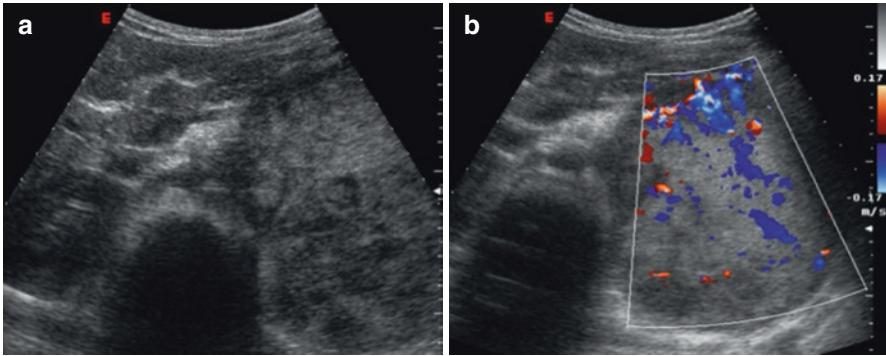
A 10-month-old boy with left adrenal neuroblastoma. Ultrasonography showed a left oval, slightly hyperechoic suprarenal mass with sharp margins (a), richly vascularized on colour Doppler (b)
